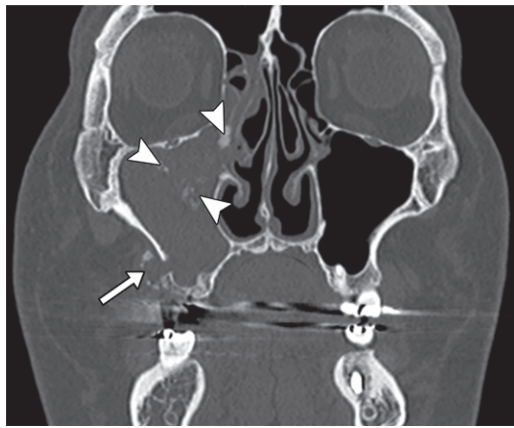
Bone graft fragmentation. Coronal nonenhanced CT image (bone window) shows complete opacification of the right maxillary sinus. The bone graft material is diffusely dispersed inside the sinus (arrowheads) and adjacent to a bony discontinuity at the maxillary sinus floor (arrow).
